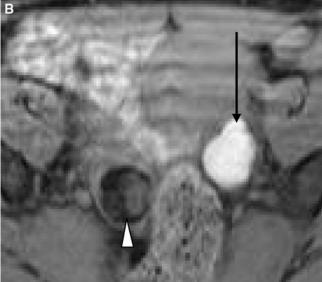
30-year-old patient. A Transverse T1-weighted flash 2D image. Homogeneous hyperintense cystic lesion in the left ovary (*arrow*) and heterogeneously hyperintense lesion in the right ovary (*arrow head*). B Transverse T1-weighted flash 2D image with fat suppression. This sequence allows differentiation of the fatty content in the dermoid cyst in the right ovary, which appears hypointense (*white arrowhead*) from blood content in the endometrial cyst in the left ovary that appears hyperintense (*black arrow*).
